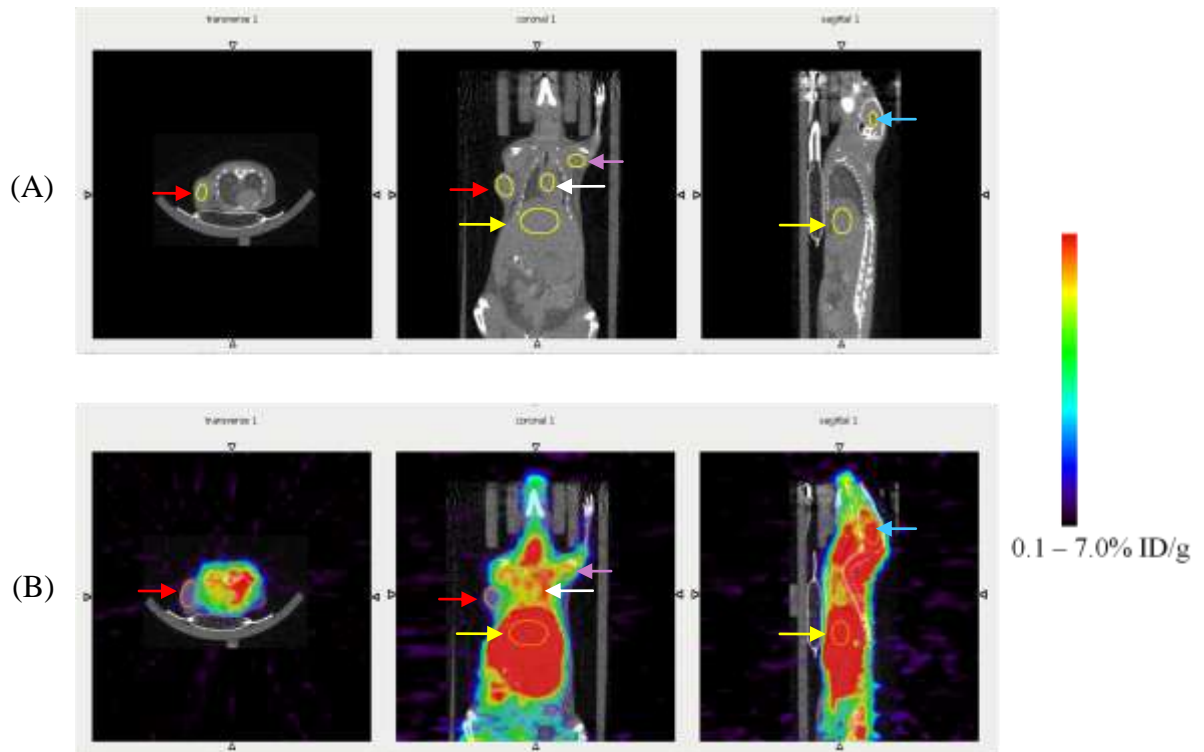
Dynamic PET image 6-7 minute pi: ROIs for tumour (transverse and coronal view, red arrow), heart (coronal view, white arrow), liver (coronal and sagittal views, yellow arrow) and muscle (coronal view, purple arrow). (A) CT image (B) PET/CT image. PET colour indicating 0.1-7.0% ID/g
